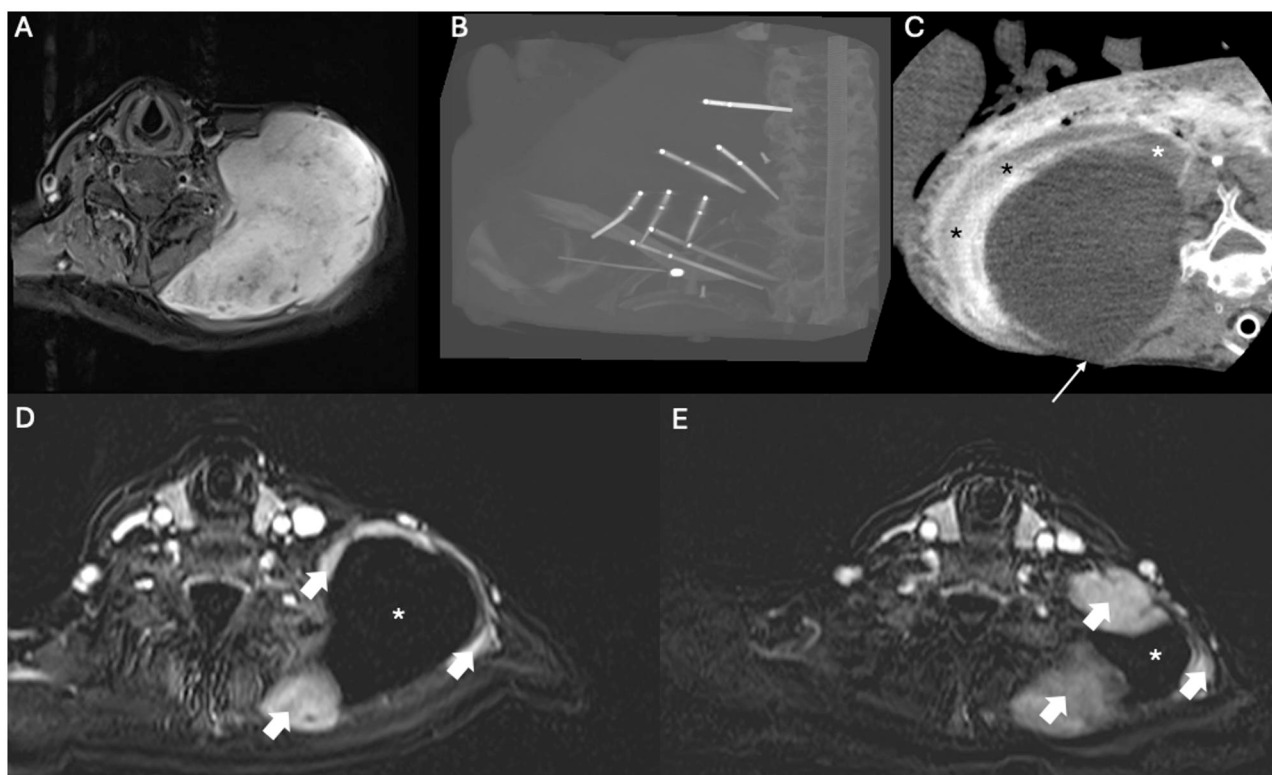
CA of a large DF in the neck. Axial contrast-enhanced MRI (A) shows a 11-cm tumour. Treatment was made with 8 cryoprobes (B). Final axial CT scan (C) shows the hypodense iceball with some unablated tumour (white asterisk). Note the hydrodissection of the skin (black asterisks) which fails to separate the skin anteriorly with a focal contact of the ice with the skin (arrow). 6 months (D) and 18 months (E) contrast-enhanced MRI shows the necrosis (asterisk) which shrinks progressively. Nodular enhancement is seen in the periphery of the cryoscar (large arrows) with progressive enlargement. This finding is usual following CA of a DF. In the absence of pain, the patient was simply followed without any treatment. Skin fistula occurred at the level of skin freezing, with chronic effusion still persistent at last follow-up. Abbreviations: CA = cryoablation; DF = desmoid fibromatosis.
